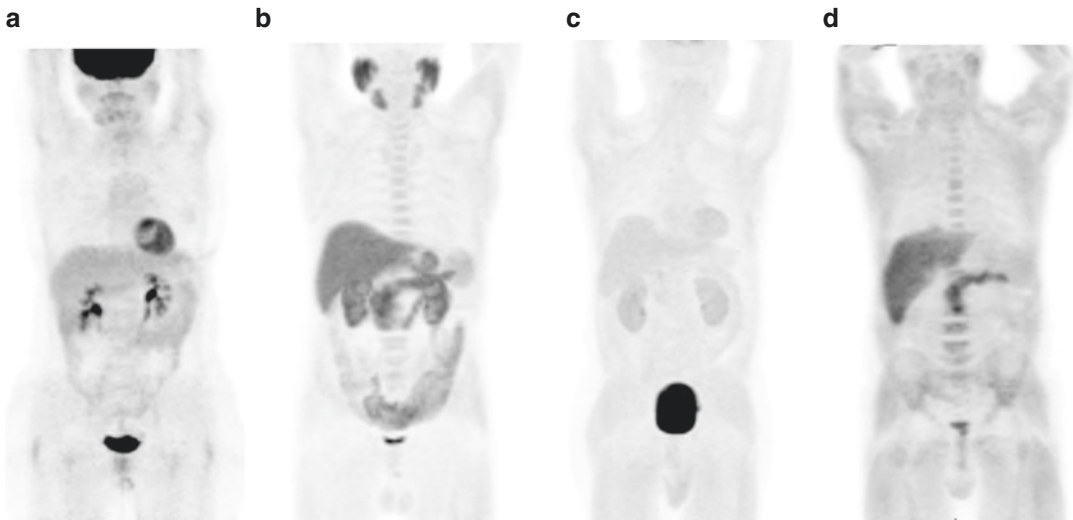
Biodistribution of PET tracers: ^{18}F -FDG (a), ^{18}F -FCH (b), ^{18}F -DOPA (c), ^{18}F -Fluociclovine (d)
